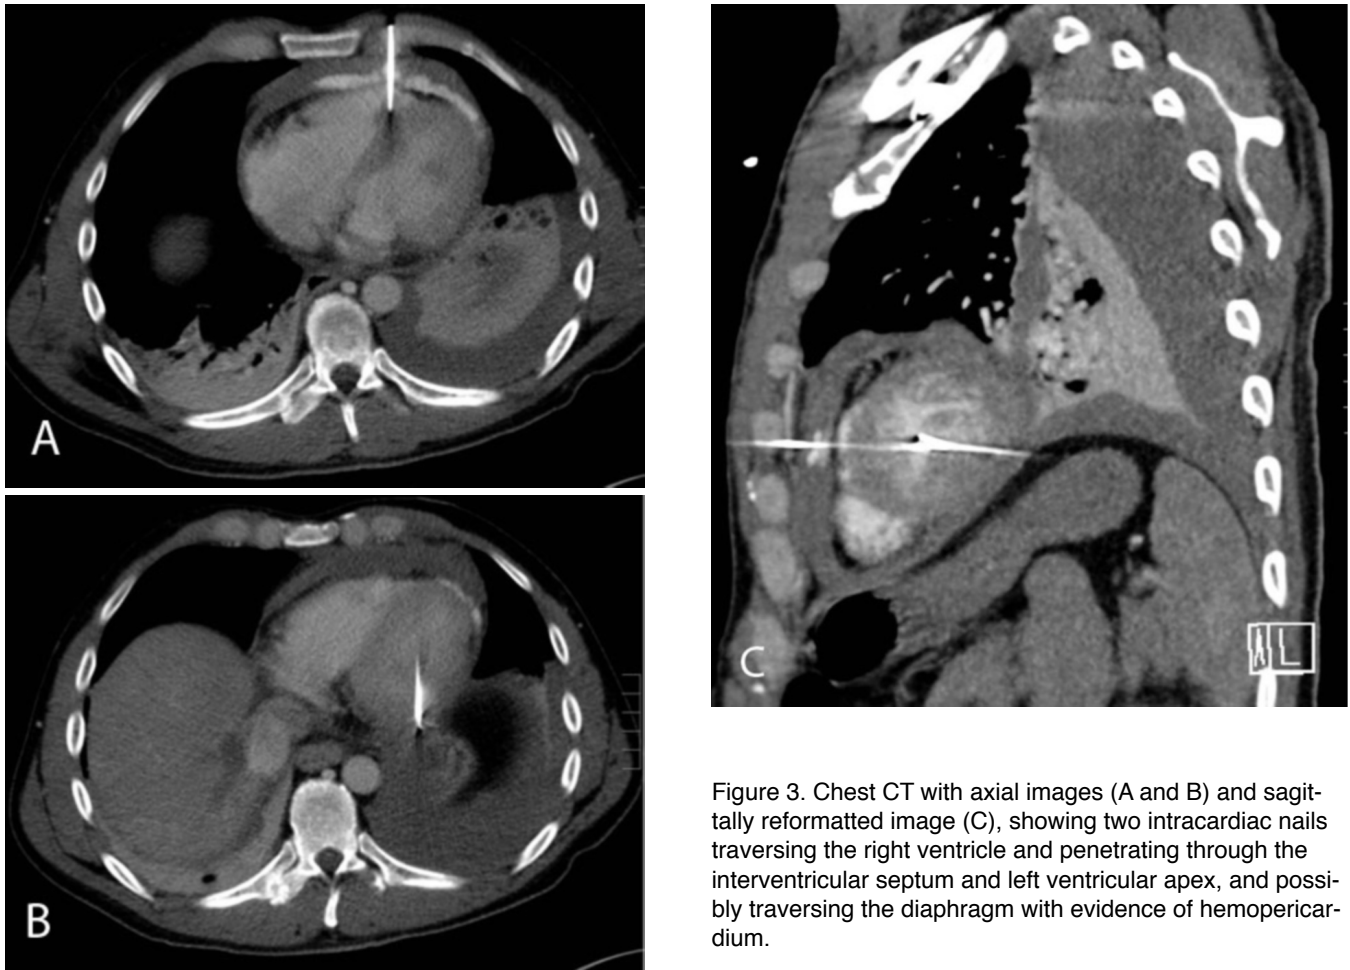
Chest CT with axial images (A and B) and sagittally reformatted image (C), showing two intracardiac nails traversing the right ventricle and penetrating through the interventricular septum and left ventricular apex, and possibly traversing the diaphragm with evidence of hemo-pericardium.
